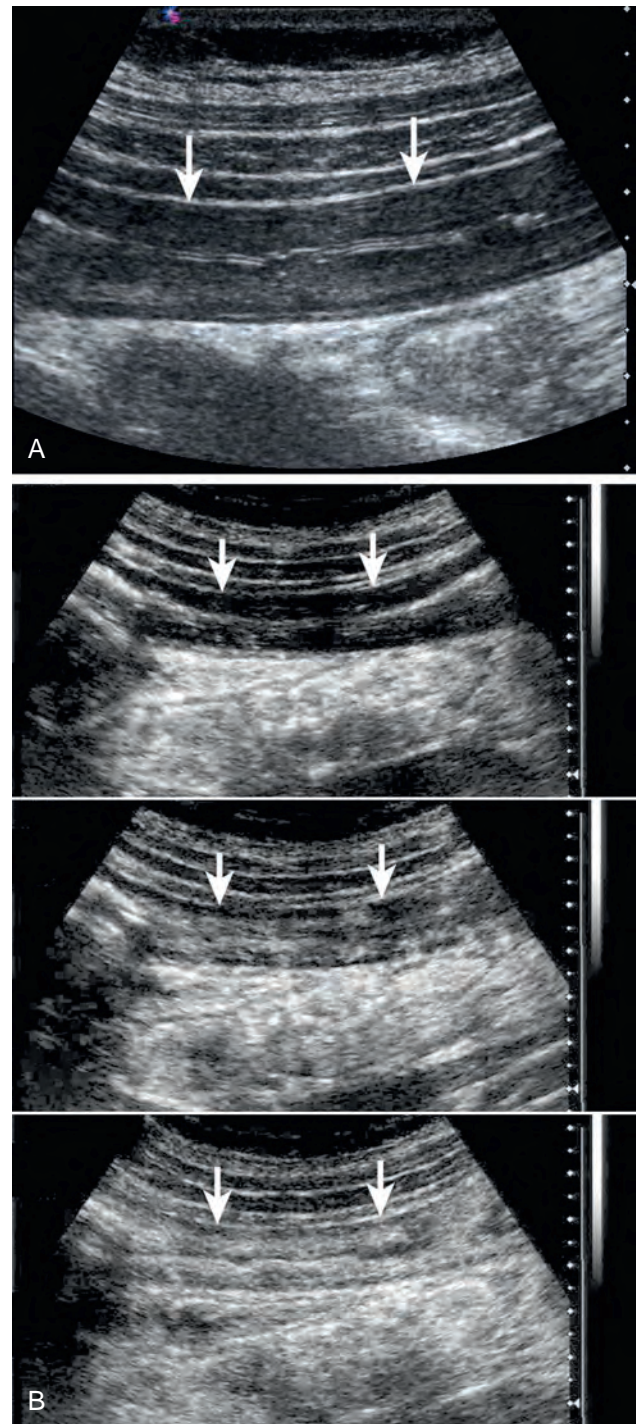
Ischemic bowel. A. Longitudinal section of the descending colon (arrows) shows hypoechoic wall thickening, with barely visible stratification. Color Doppler sonography (not shown) detected only minimal flow in the periphery of the bowel wall. B. Contrast-enhanced ultrasound clearly demonstrated vascularization of this segment (arrows), requiring no urgent surgical intervention. (From Hollerweger A: Colonic diseases: The value of US examination. *Eur J Radiol* 64:239–249, 2007.)
